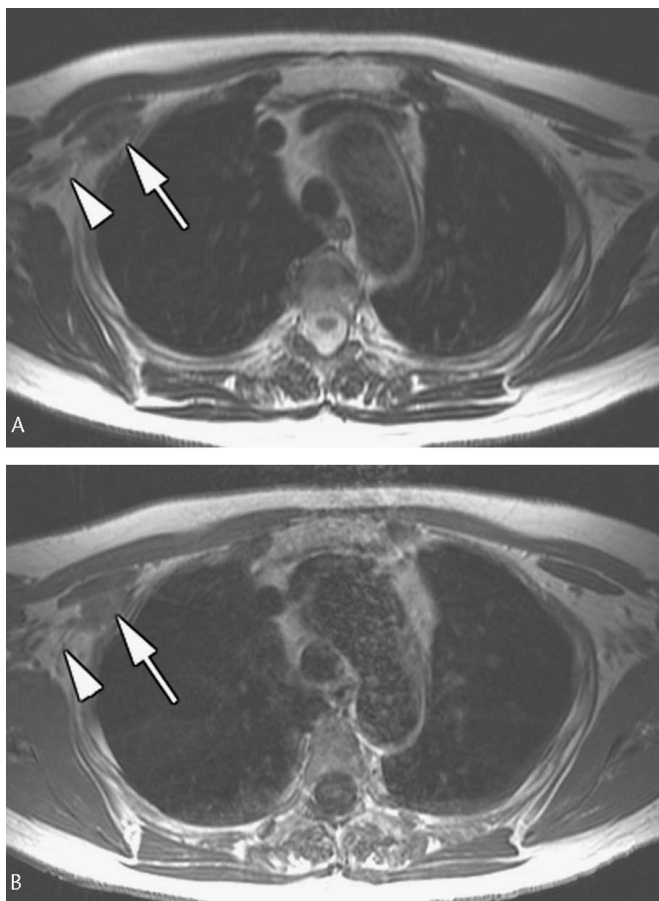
Metastatic involvement by breast cancer. A, Axial precontrast T1-weighted image shows tumor (arrow) adjacent to the brachial plexus cords (arrowhead). B, Axial postcontrast T1-weighted image demonstrates enhancement of tumor (arrow) adjacent to the brachial plexus cords (arrowhead).
